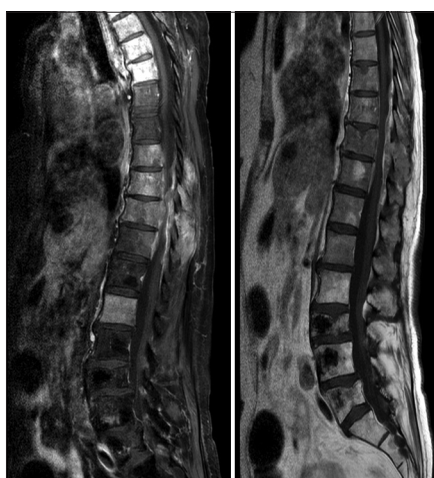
Preoperative spine magnetic resonance imaging sagittal images documented vertebral metastatic involvement at the thoracic and lumbar levels, specifically at Th9, Th10, Th11, L1, L2, and L3 with spinal cord compression at the Th9-Th11 level
